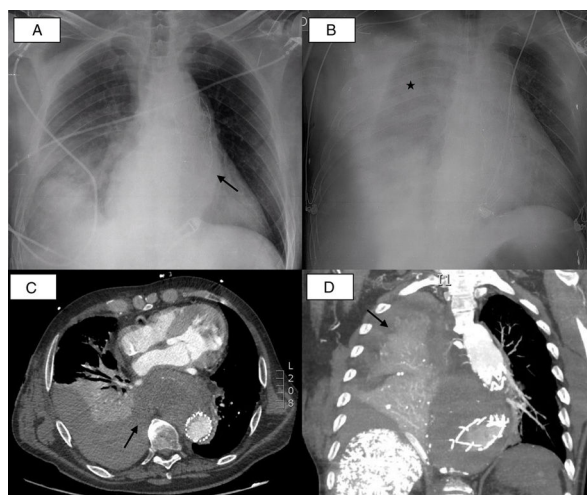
(A) Anteroposterior chest X-ray at admission: cardiomegaly, aortic elongation with stent (arrow) and area of increased density in the right thoracic base probably related to infectious disease. (B) Anteroposterior chest X-ray after clinical worsening: significant pleural effusion with opacities in the right hemithorax (asterisk). (C) Chest CT in axial plane. (D) Chest CT in sagittal plane: endoleak can be seen in the descending thoracic aorta with extravasation in the form of active bleeding into the right pleural cavity causing significant hemothorax (arrows), collapsing the entire right lower lobe and the posterior segment of the upper lobe (aortopleural fistula).
